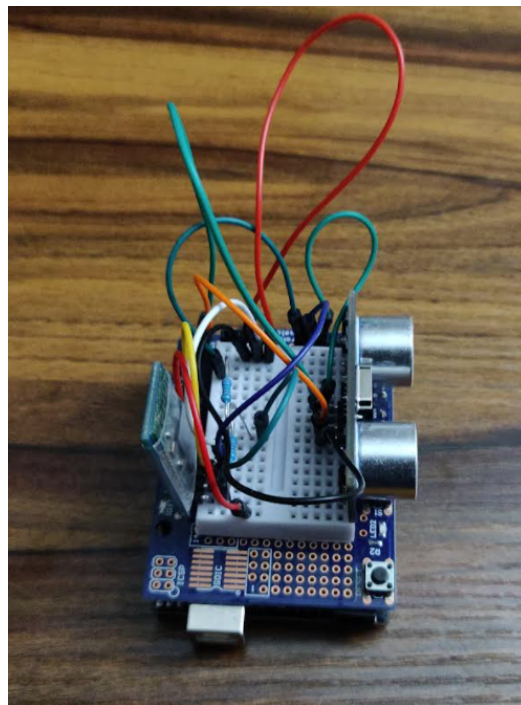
Arduino Uno setups with Ultrasound sensor and Bluetooth module attached
